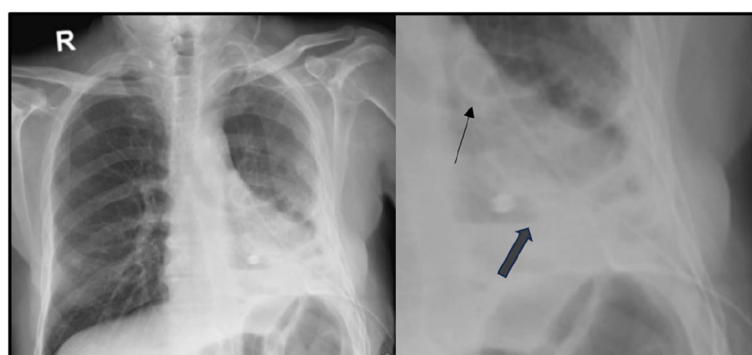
Chest X-ray showing left-sided pleural effusion and retained broken intrapleural catheter and intercostal drainage tube (ICDT). In a closer view, the pigtail is marked with a thin arrow, while the ICDT is marked with a thick arrow
